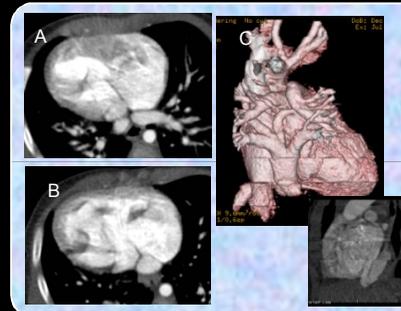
Pre-operative cardiac CT showing an infracardiac TAPVC patient who was also born with dextrocardia, RAI (Fig. 1A) and a hypoplastic LV (Fig. 1B). Note there is junctional stenosis and kinking of pulmonary venous drainage (Fig. 1C) in this patient. The patient passed away after three months even with multiple attempts of surgical corrections.
